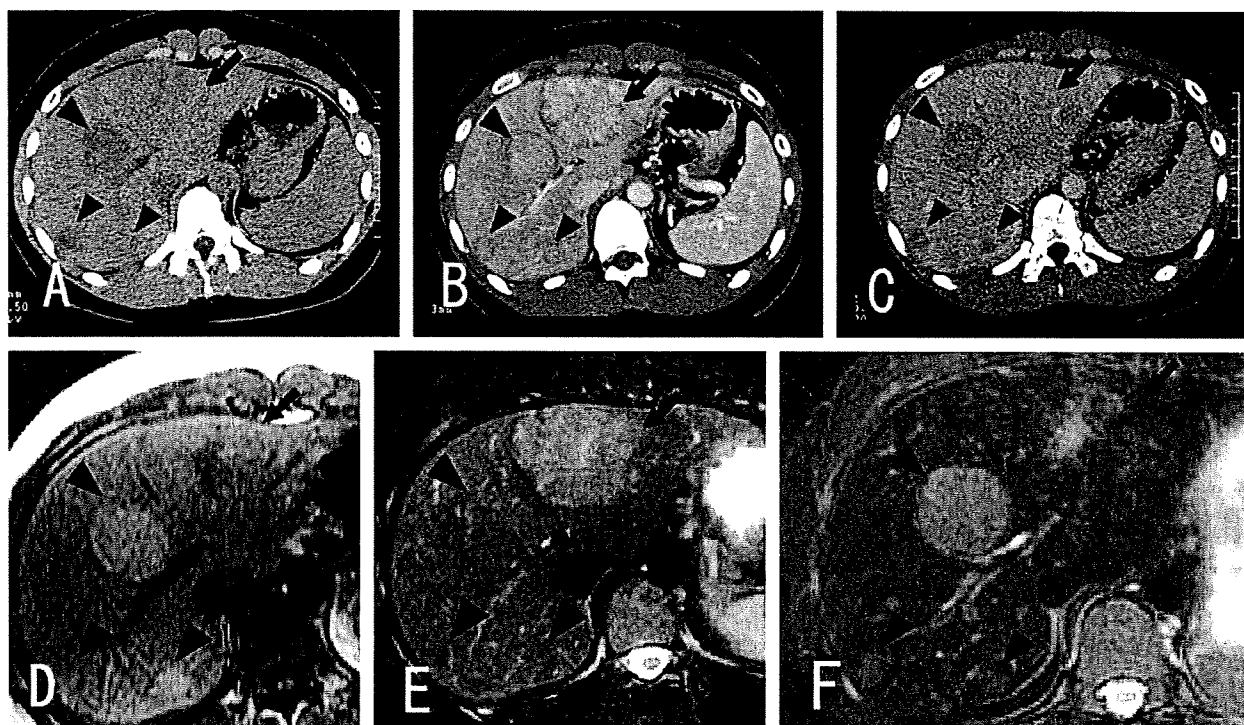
Multiple focal nodular hyperplasia (FNH) and hepatic adenoma in a patient with congenital absence of the portal vein. A Precontrast CT shows multiple mass lesions in the liver (*arrow* and *arrowheads*). B Early arterial phase contrast-enhanced CT scan shows an irregular (spoke-like) enhancing mass with a peripheral hypodense rim (*arrow*) in the lateral segment of the liver and mildly enhancing masses (*arrowheads*) in the right and medial segments of the liver. C On a portal phase contrast-enhanced CT scan, the mass in the lateral segment revealed slight enhancement (*arrow*), whereas other masses (*arrowheads*) appeared hypodense relative to the liver. The intrahepatic portal vein is not recognized.
